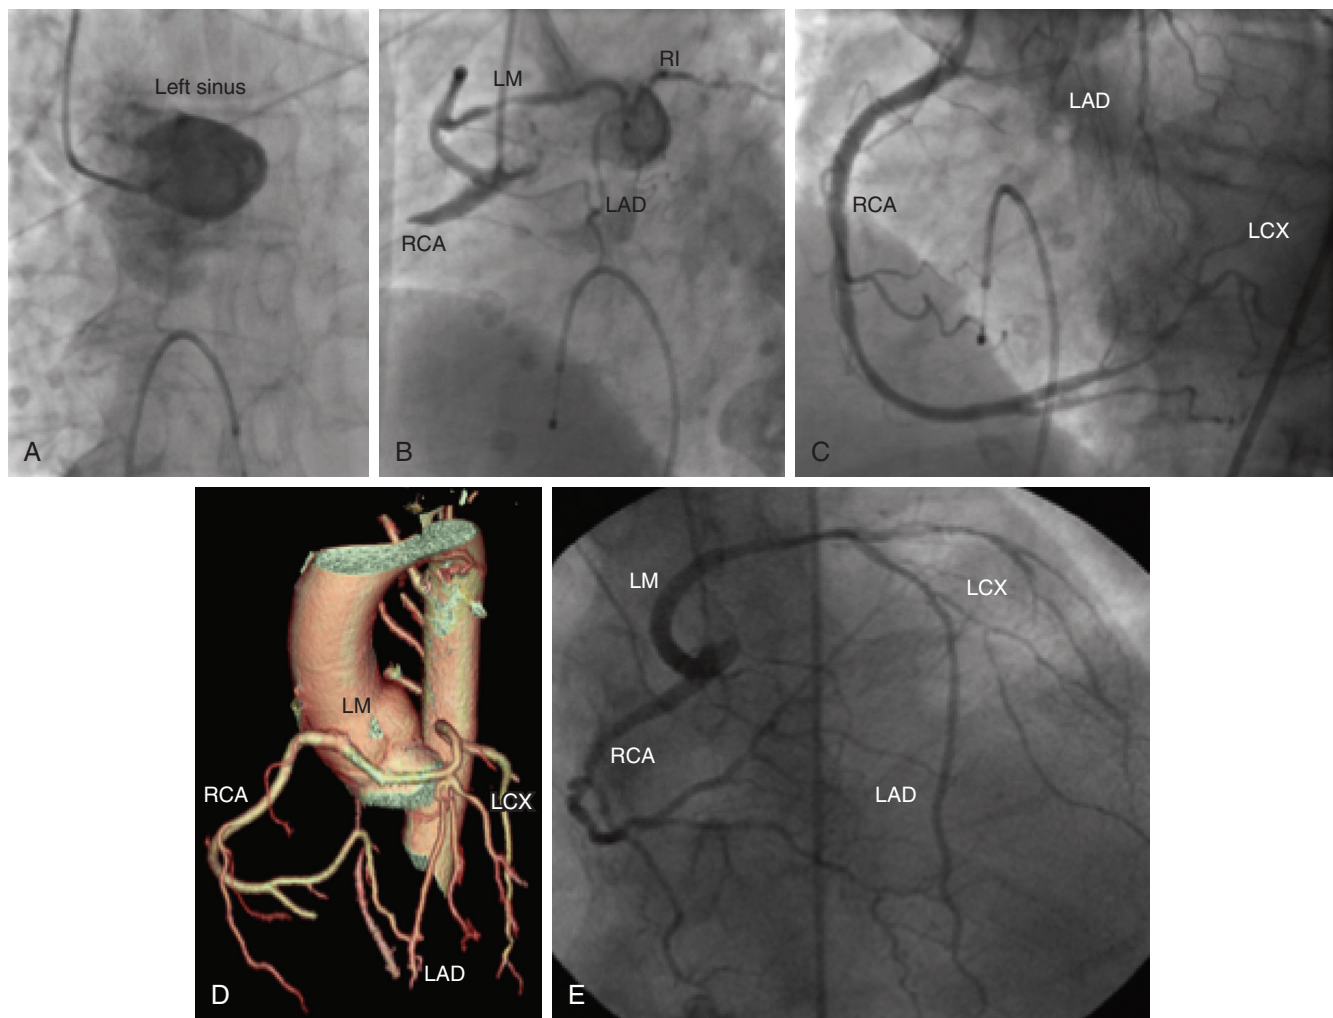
■ A, Nonselective angiogram of the left coronary sinus in an 81-year-old woman presenting with an acute inferior myocardial infarction and cardiogenic shock, demonstrating absence of coronary arteries arising from the left coronary cusp. B, Selective angiogram of the right coronary artery in the same patient revealing an anomalous origin of the left main coronary artery (LM) from the right coronary artery (RCA) and acute thrombotic occlusion of the proximal RCA. C, Angiography in the same patient after successful angioplasty of the RCA, now also demonstrating well-established collateral vessels to a severely diseased left circumflex coronary artery (LCX). D, Cardiac computed tomography angiogram three-dimensional reconstruction with virtual dissection of a similar anomalous LM arising from the RCA in a 21-year-old woman. E, Angiogram from a 54-year-old man with similar anatomy in the left anterior oblique cranial projection. The entire coronary system is visualized from a single ostium located at the right coronary sinus. The RCA and LM trunk arise together, and the LM divides into the left anterior descending (LAD) and LCX branches. *RI*, Ramus intermedius coronary artery.
